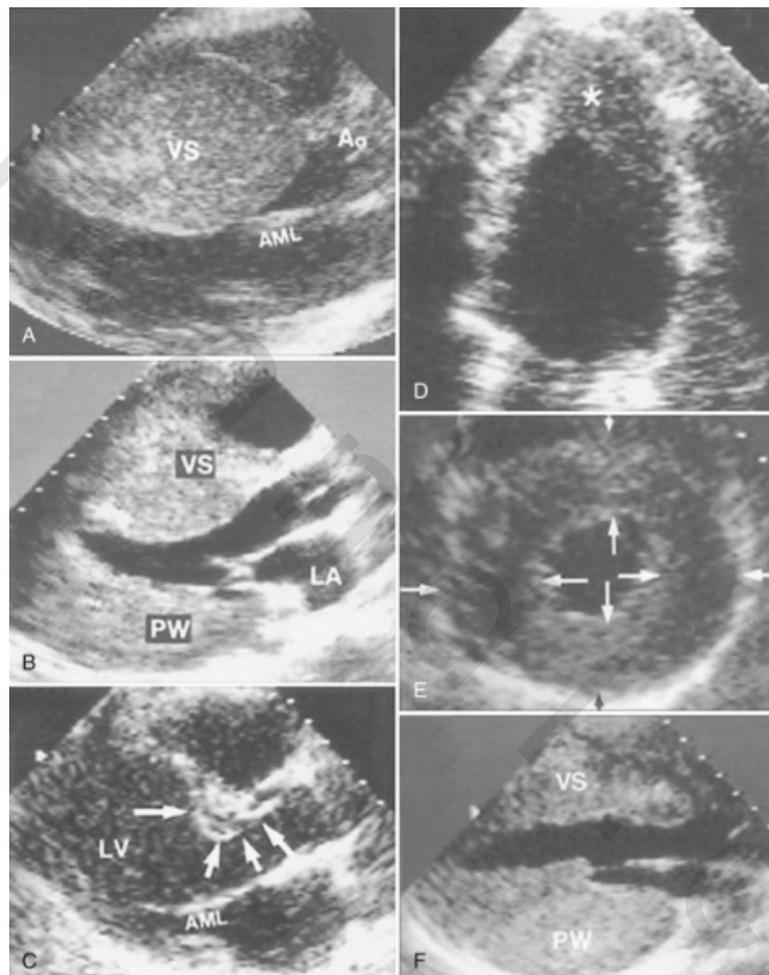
Patterns of LV hypertrophy in HCM⁽⁸⁵⁾. Heterogeneous distribution and extent of LV wall thickening by echocardiography. A, Massive asymmetric hypertrophy of ventricular septum (VS) with thickness >50 mm. B, Septal hypertrophy with distal portion considerably thicker than proximal region. C, Hypertrophy confined to proximal septum just below aortic valve (arrows). D, Hypertrophy localized to LV apex (asterisk), that is, apical HCM. E, Relatively mild hypertrophy in symmetric pattern showing similar or identical thicknesses within each segment (paired arrows). F, Inverted pattern with posterior free wall (PW) thicker (40 mm) than anterior VS. Calibration marks = 1 cm. Ao = aorta; AML = anterior mitral leaflet; LA = left atrium.
